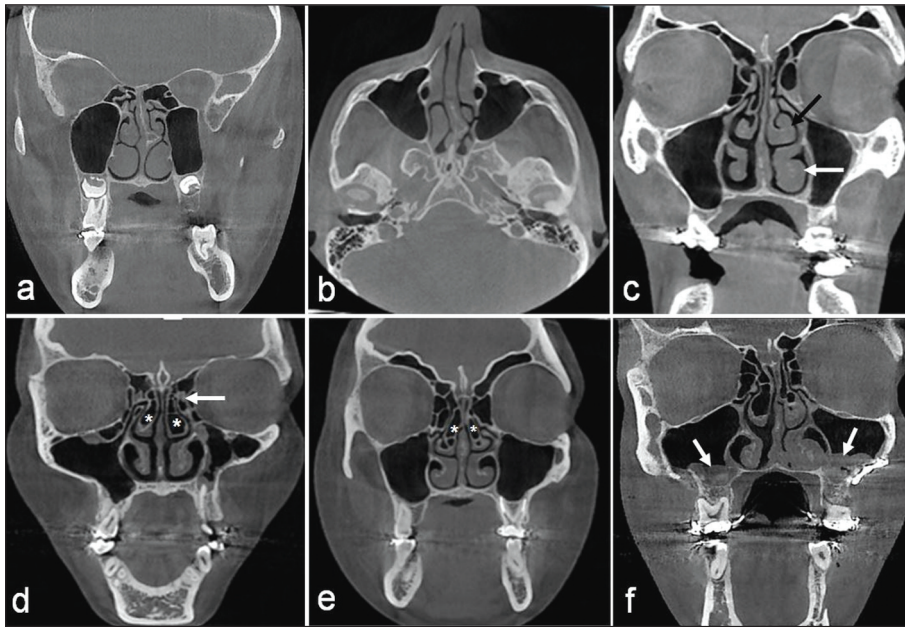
CBCT images of some of the sinonasal anatomical variations and pathologies observed. a, b) Coronal and axial scans; NSD with septal spur; c) Coronal scan; unilateral MCH (black arrow) and ICH (white arrow); d) Coronal scan of a patient with normal maxilla position; right UPP (arrow) and bilateral CB (asterisks); e) Coronal scan of a patient with maxillary prognathia; bilateral CB (asterisks); f) Coronal scan of a patient with maxillary retrognathia; bilateral CB with together the mucosal thickening of the both maxillary sinuses (arrows).
